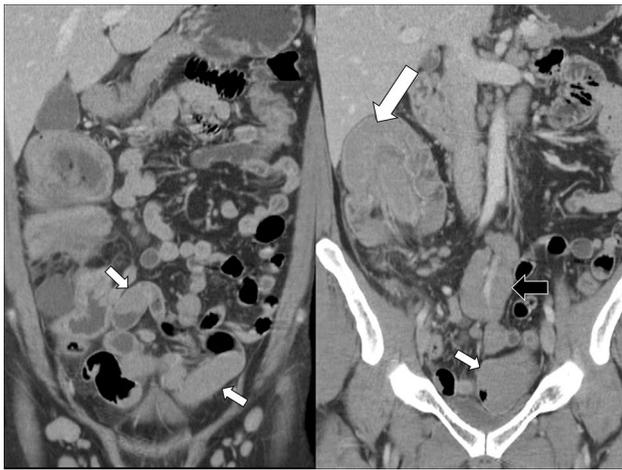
A 36-year-old man with acute abdominal pain caused by ileocolic intussusception. Coronal CT images show a bowel-in-bowel configuration with a leading mass (large arrow, right). Multiple enhancing polypoid intraluminal masses are seen in the ileal loops (small arrows, both). In addition, note multiple enlarged lymph nodes at the mesentery (black arrow, right) and both inguinal regions (left figure). After surgical resection, multiple ileal masses were confirmed to be mantle cell lymphoma
